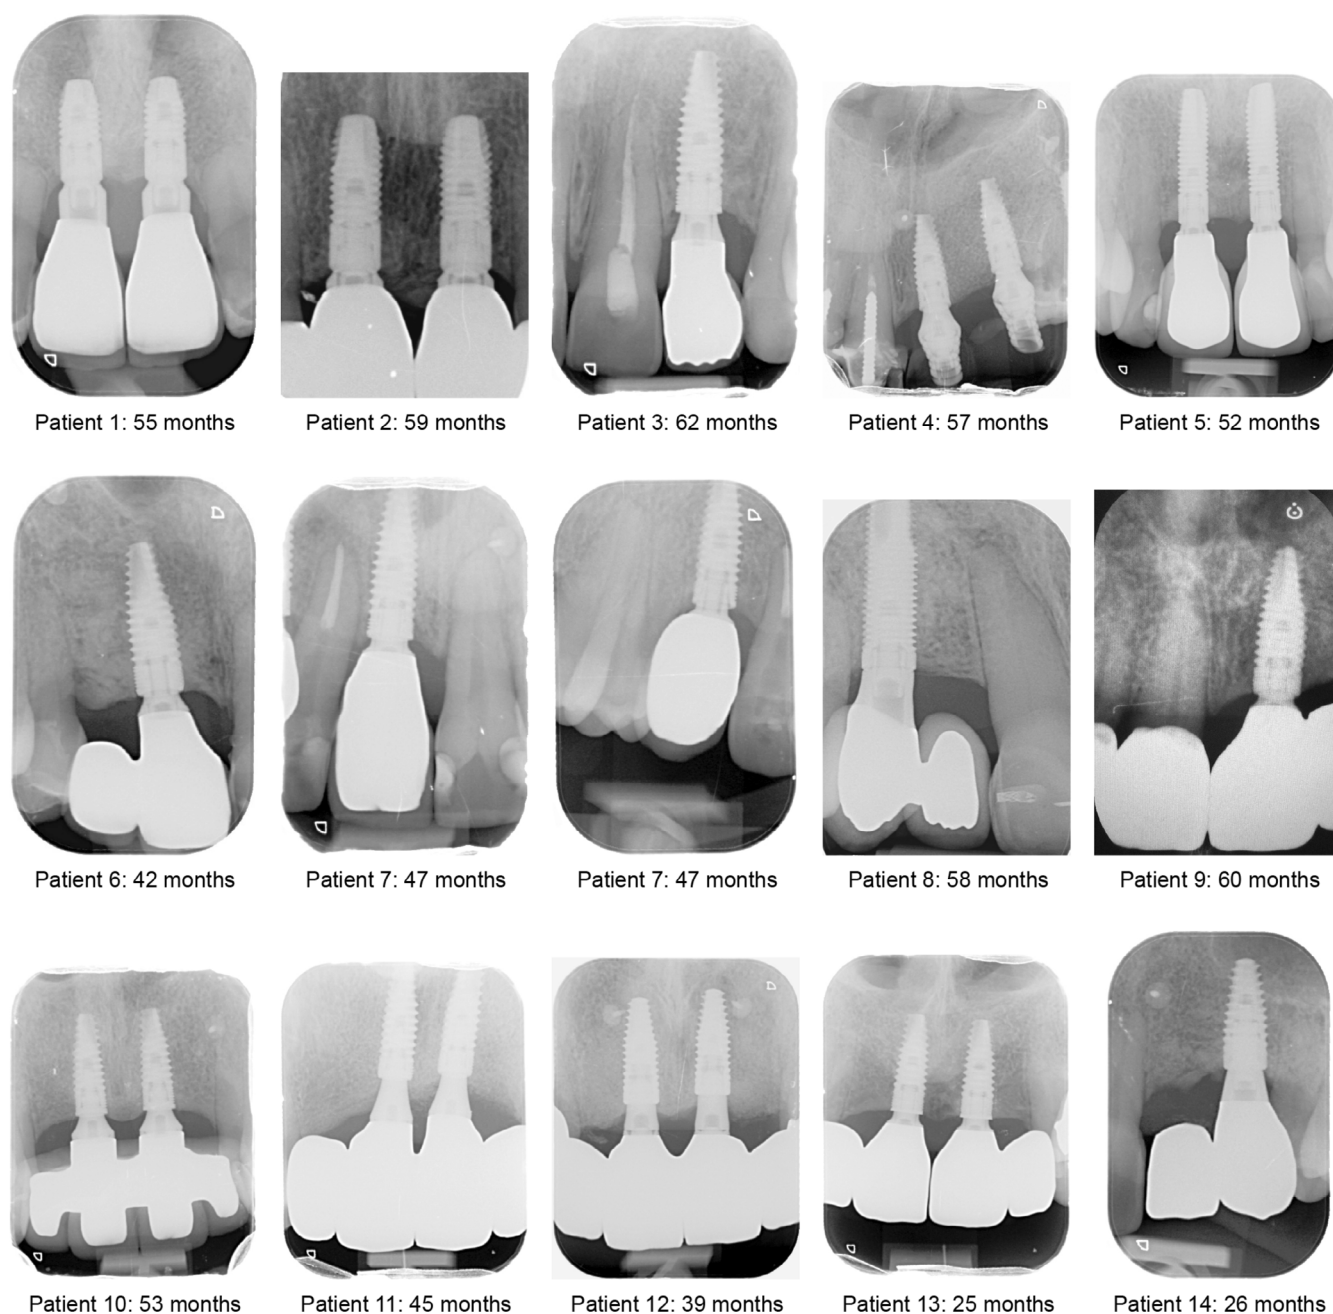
Radiographs of all study patients at the time of the latest radiographic follow-up. Time indicates the number of months after implant loading.
